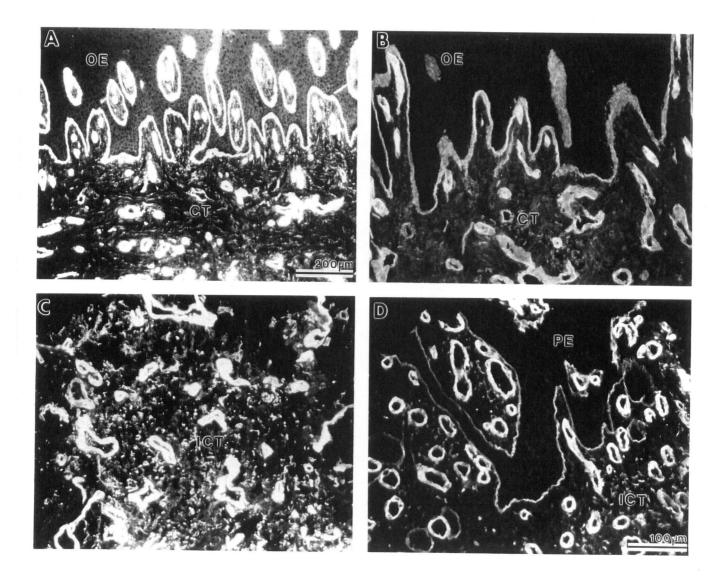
Immunolocalization of LM-1 (A and C) and type IV collagen (B and D) in healthy (A and B) and in chronically inflamed periodontal tissue (C and D), respectively. OE; oral epithelium; CT; connective tissue; PE; periodontal epithelium in chronic inflammation; ICT; inflamed connective tissue. Bar 200 μ m: A; bar 100 μ m: B, C, D.
